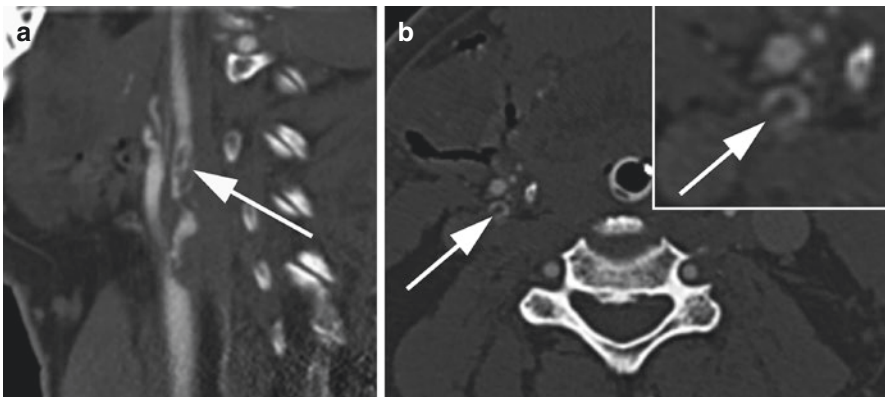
Carotid intraluminal thrombus. Sagittal (a) CTA image through the right ICA demonstrates intraluminal thrombus with intraluminal low attenuation clot (arrow). This has the characteristic ‘donut sign’ on axial images (b, inset) with central clot (arrow) surrounded by high attenuation contrast
